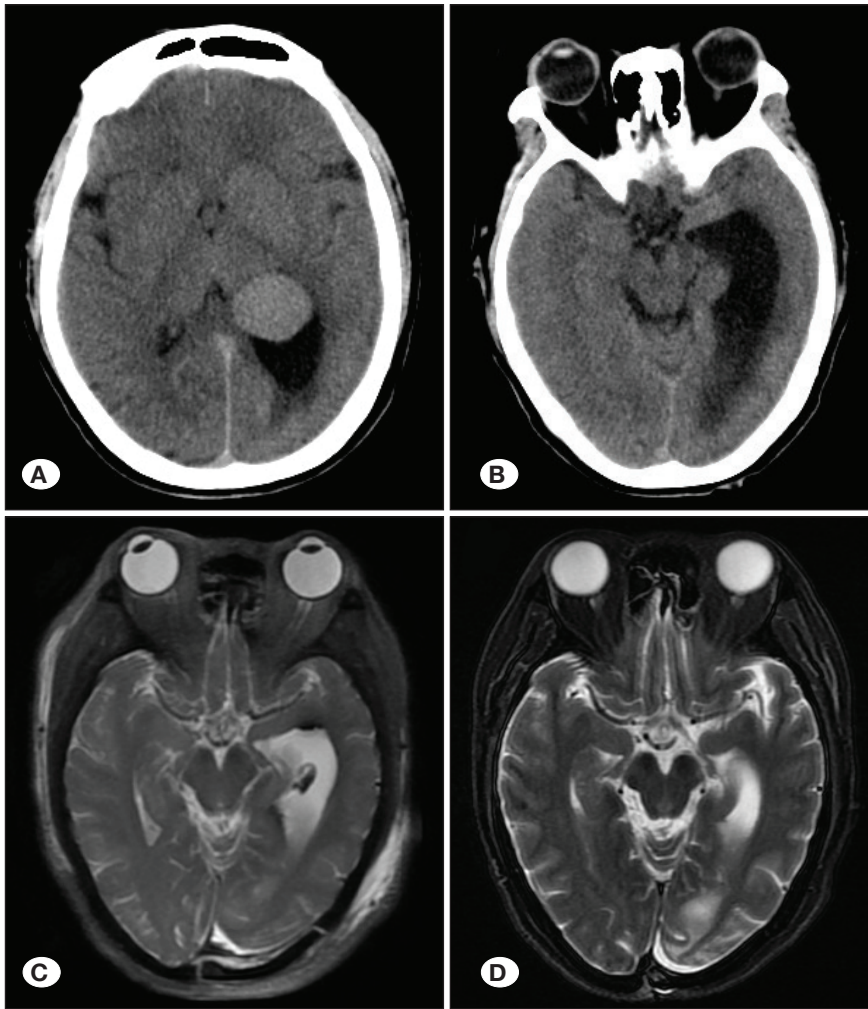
A, B) Preoperative CT. C) MRI re-examination before discharge on postoperative day 5. D) MRI re-examination 1 year post-surgery.
